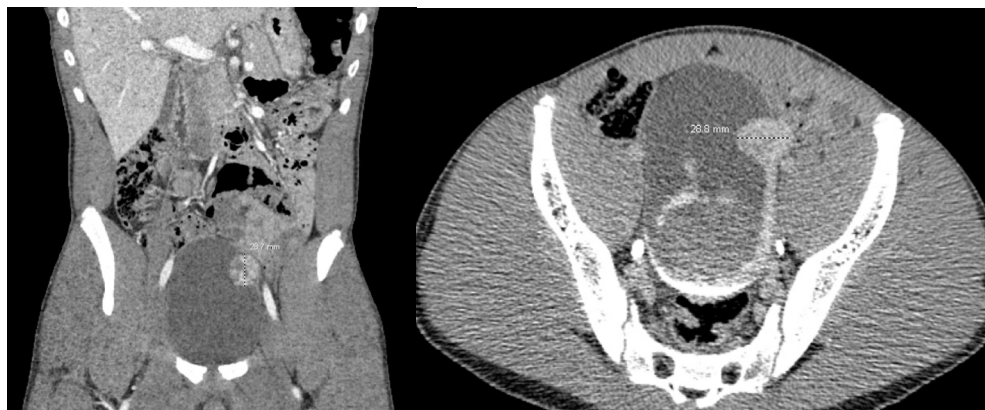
Initial CT imaging demonstrating the 2.87 cm left posterolateral bladder wall mass.
